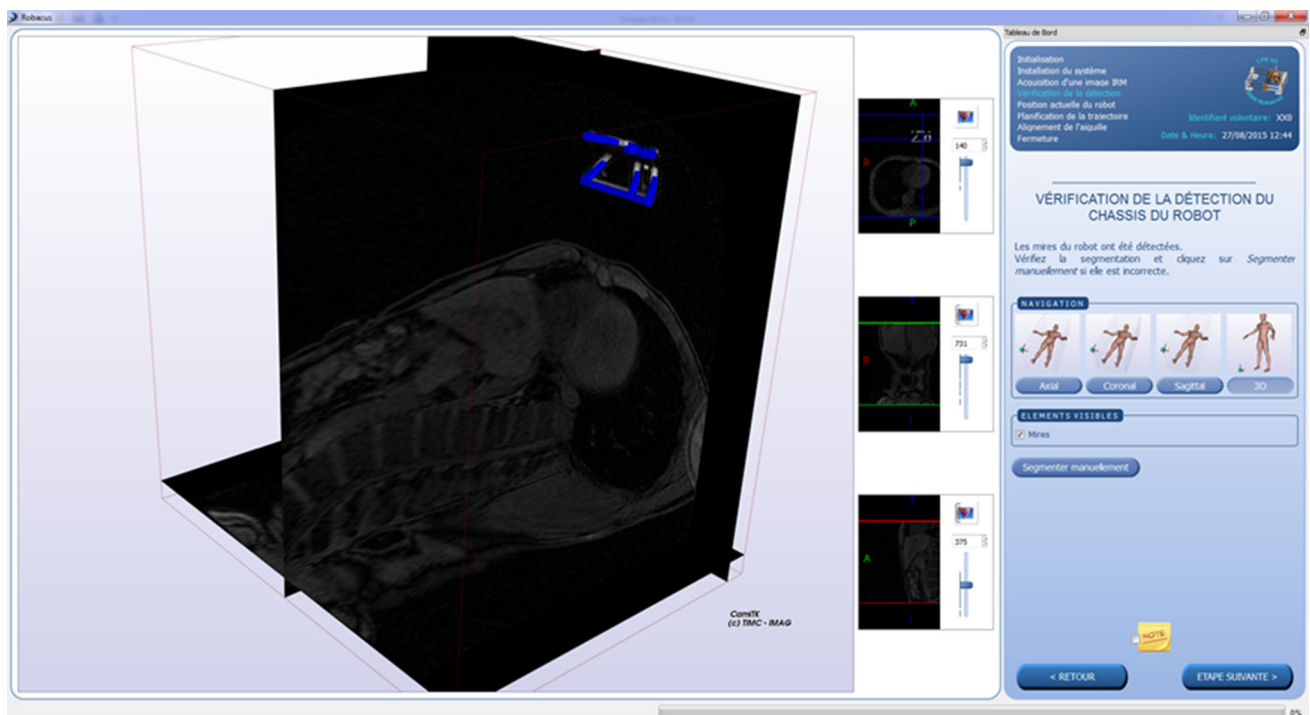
Screenshot showing the “robot frame” fiducial displayed over a 3D representation of the MR image. This screen was used by the radiologist to verify the fiducial segmentation
